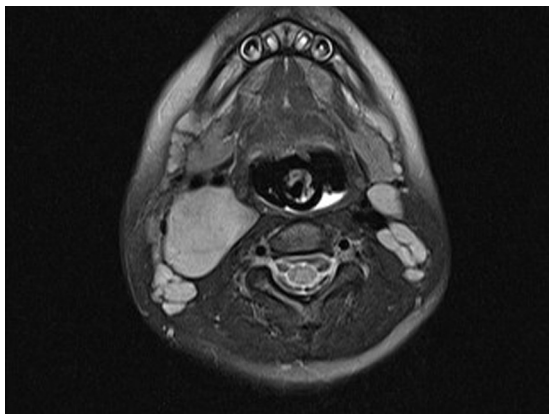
Case 1 MRI showing 5.5 cm × 3.8 cm × 3.1 cm mass lesion in the right neck displacing the carotid artery anteriorly. The right internal jugular vein is effaced.
